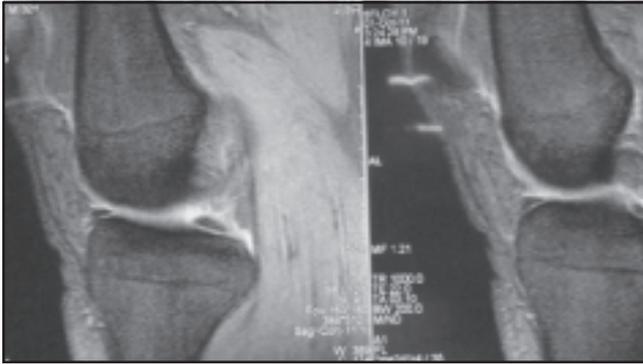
MRI shows complete ACL tear
